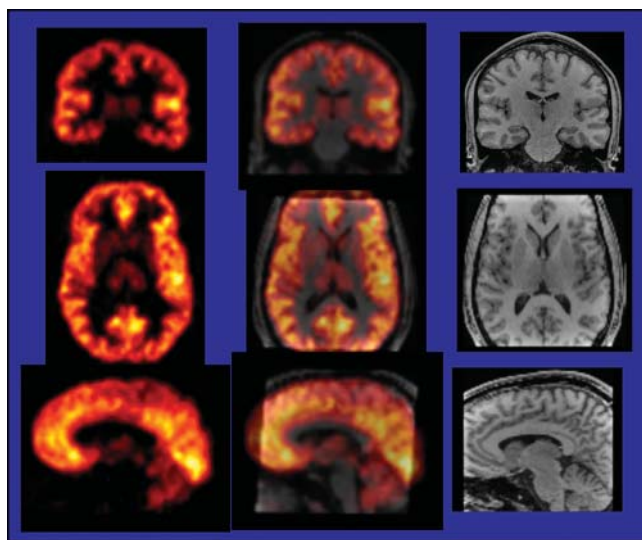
Central benzodiazepine receptor mapping study with ¹⁸F-flumazenil PET (left) and fusion (middle) with MR images (right).
